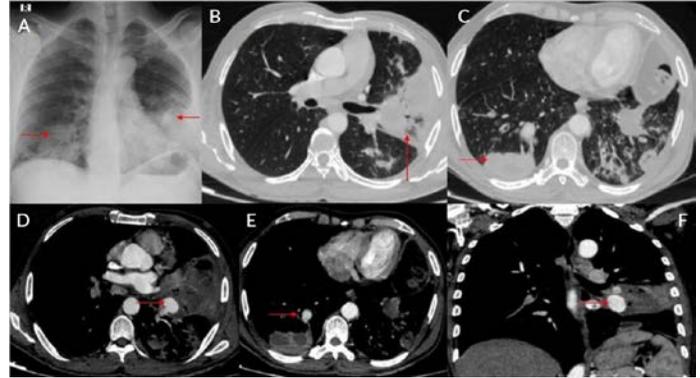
Bilateral pseudoaneurysm embolized using Amplatzer vascular plug (Abbott). (A) Chest X-ray posteroanterior view showing areas of consolidation involving the bilateral lower zones. (B) and (C) Contrast-enhanced computed tomography (CT) of the chest axial image in lung window showing areas of consolidation with cavitations, bronchiectasis with bronchial wall thickening involving the bilateral lower lobes and lingular segments. (D), (E), and (F) Contrast-enhanced CT chest axial and coronal images in the mediastinal window show a pseudoaneurysm involving the anterior basal segmental branch of the left descending pulmonary artery and posterior basal segmental branch of the right descending pulmonary artery.
